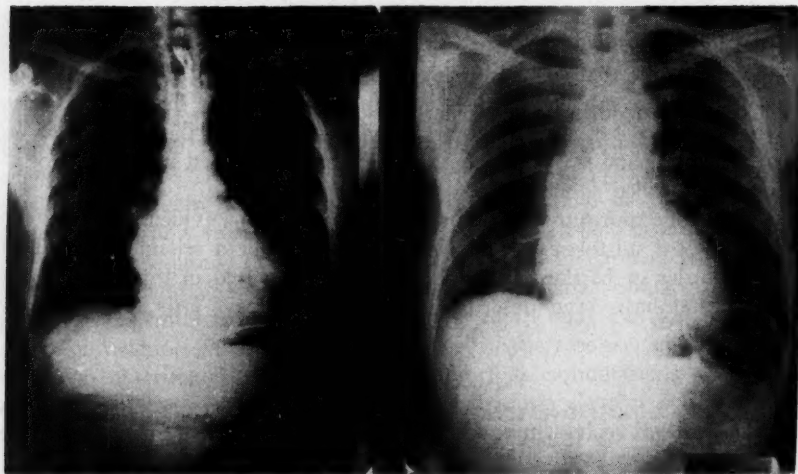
\* Cardiac x-rays in subaortic and aortic stenosis. The x-ray on the left is that of patient J. F. Note the nonspecific enlargement, left ventricular prominence, and absence of post-stenotic aortic dilatation. The x-ray on the right is from a patient with proved valvular aortic stenosis. In contrast, note the striking post-stenotic dilatation of the aorta.
